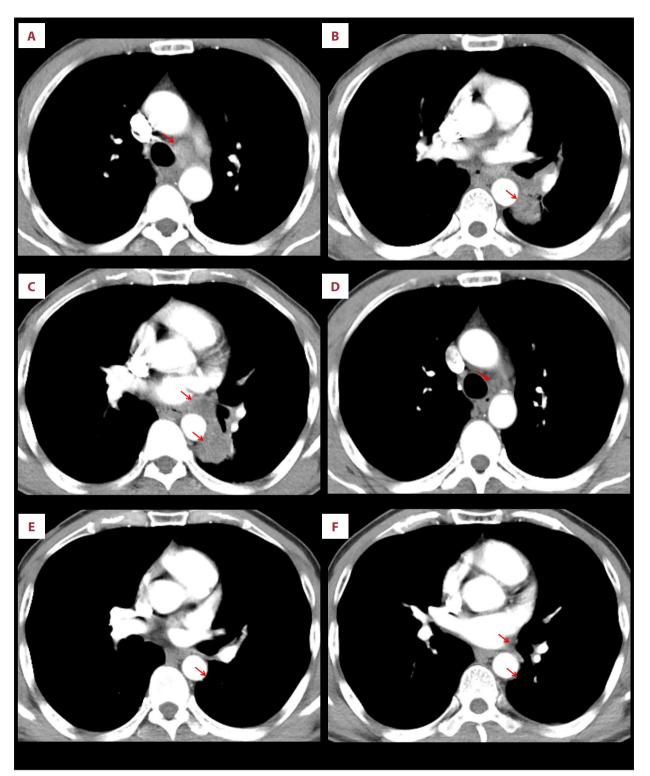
(A-F) CT images of lymph nodes before and after neoadjuvant therapy. Enhanced chest CT mediastinal window showing lymph node changes at different levels (red arrow).
